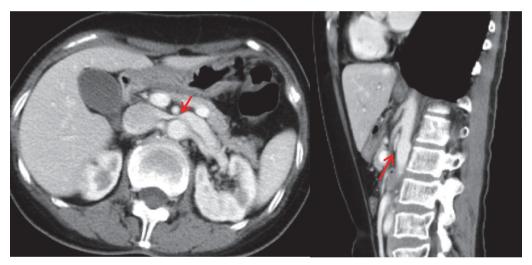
CT showed compression of left renal vein by superior mesenteric artery and abdominal aorta.
